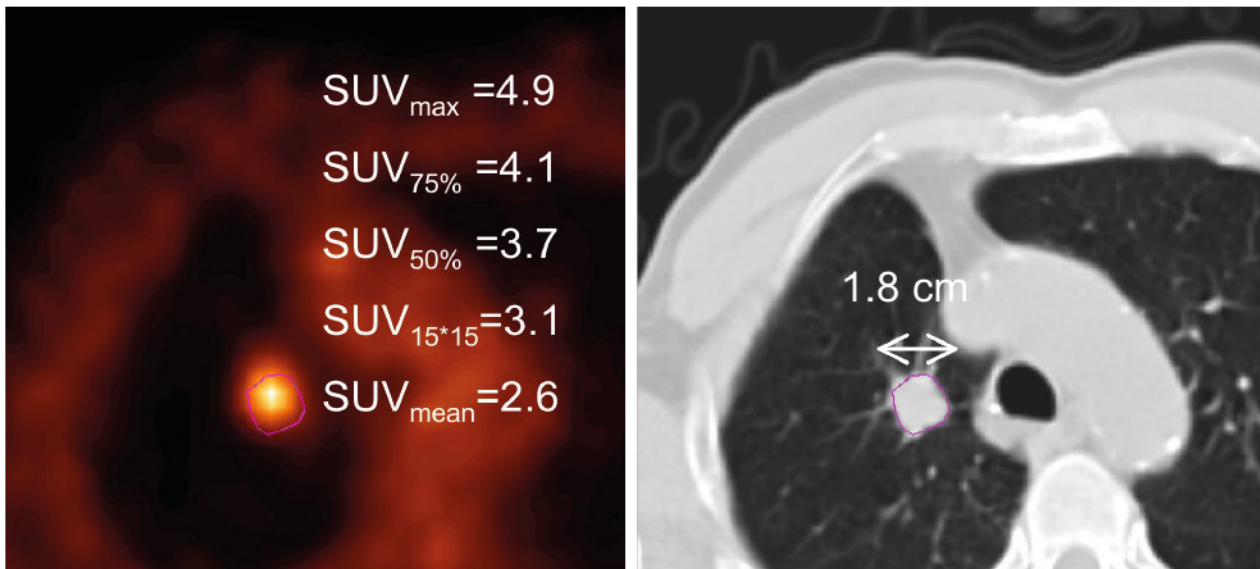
Impact of the VOI used for estimating the SUV.
